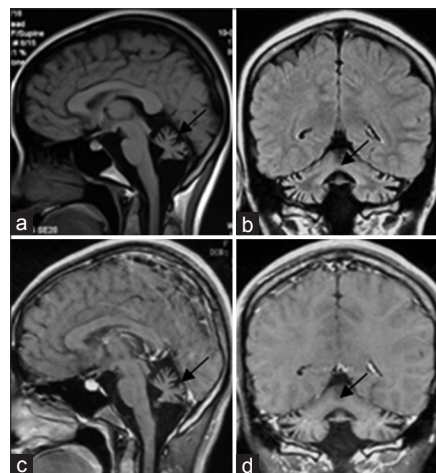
Brain MRIs: Atrophy of the cerebellar hemispheres sparing the brainstem and supratentorial structures is evident (a and c; arrows). Atrophy of the cerebellar vermis is apparent (b and d; arrows). MRI: Magnetic resonance imaging.
